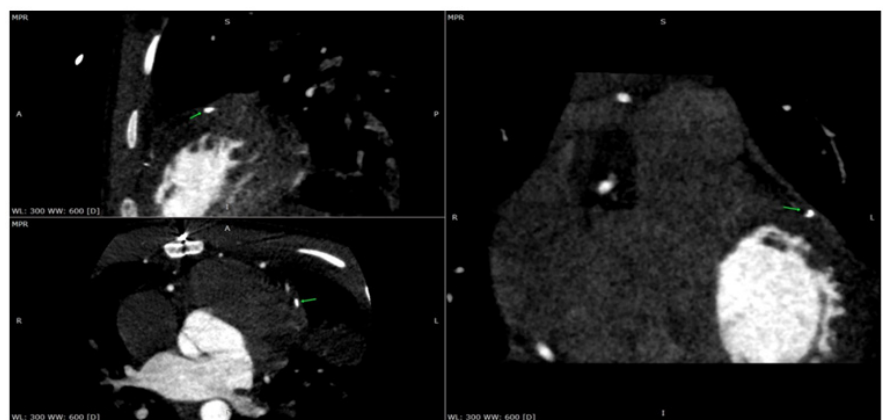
CT, mechanical occlusion of the middle segment of the LAD artery.
